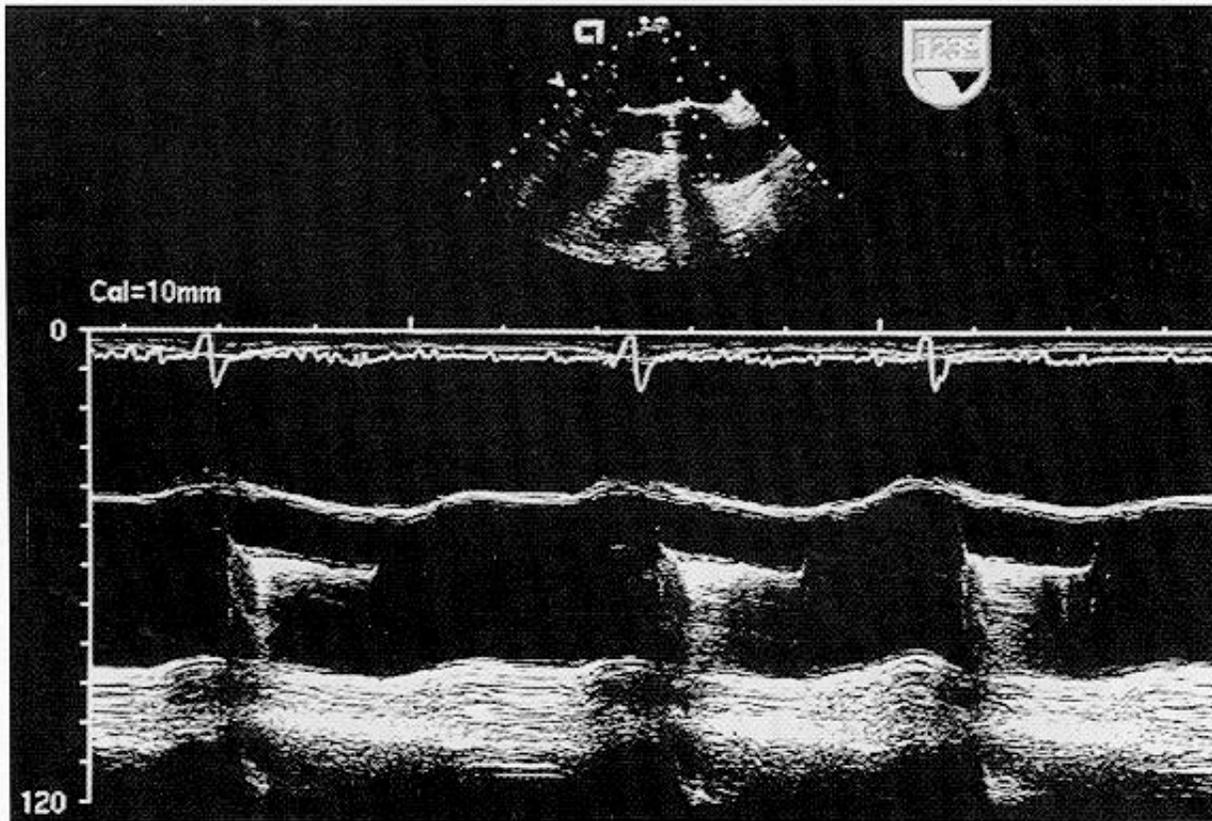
M-mode transesophageal echocardiogram (TEE) of prosthetic aortic valve disk motion. Vertical lines demonstrate rapid disk movement between open- and closed-disk positions.
